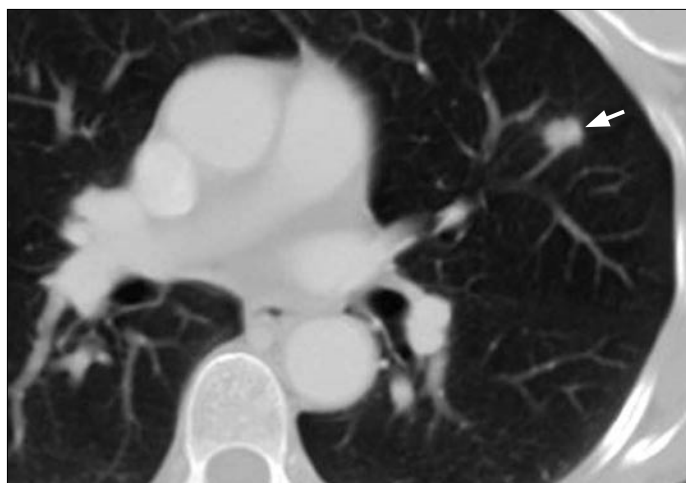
Axial postcontrast CT image shows a nodule (arrow) in the upper lobe of the left lung.
